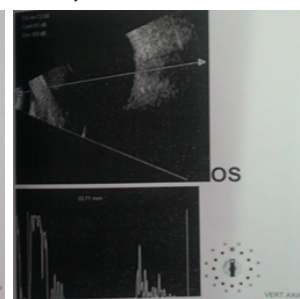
A B-scan ultrasonography of left eye showing cataractous lens
